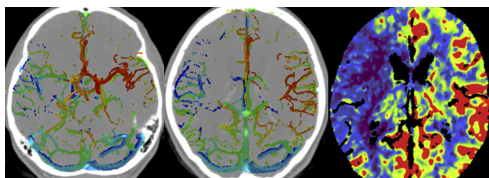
Color-coded CT angiography, a recent innovation with applicability in acute infarction, is shown in a patient with an occlusion of the right internal carotid artery. At the 2 levels presented, there is delayed flow within the right middle cerebral artery (MCA) vessels, with collateralization via the anterior communicating artery to the MCA. From the CT perfusion study, cerebral blood flow is markedly reduced as well in the right MCA territory. Reprinted with permission from Thierfelder et al.¹⁶ Figure 2 can be viewed online in color at www.investigativeradiology.com.
